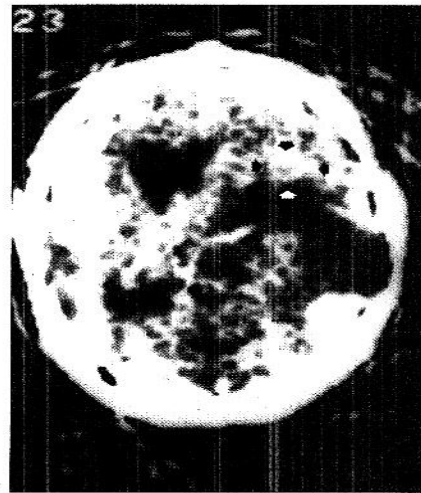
Contrast enhanced CT scan, showing a hyperdense right parieto-occipital lesion with marked oedema extending anteriorly (thin black arrows). The scanty visible isodense right temporal lesion (large arrowheads) was not recognized at first
